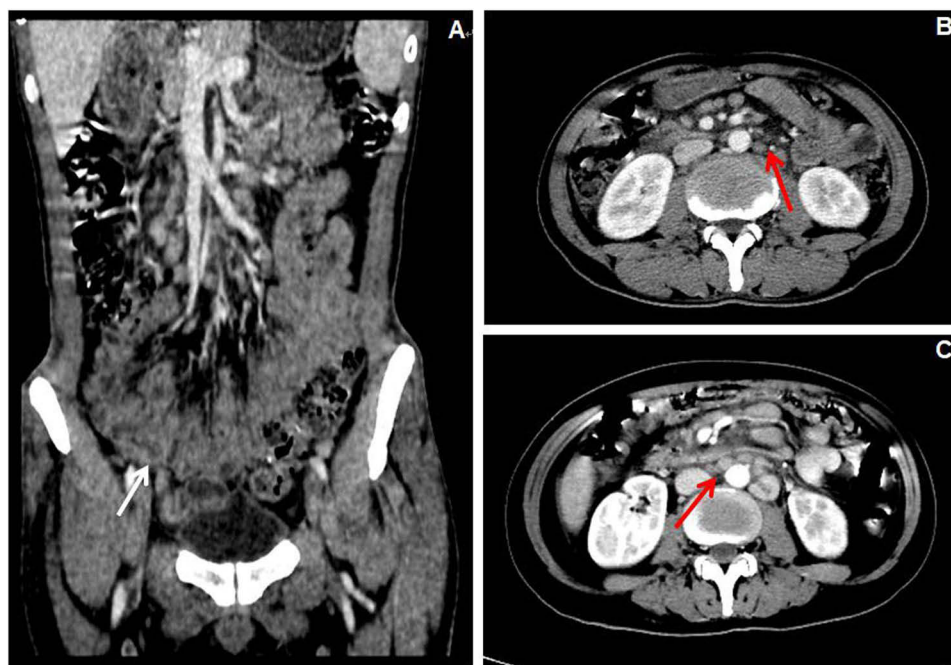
Enhanced abdominal CT (A–C) showing significant lymph node enlargement (red arrows) and multiple areas of thickening of the intestinal wall (white arrow).
